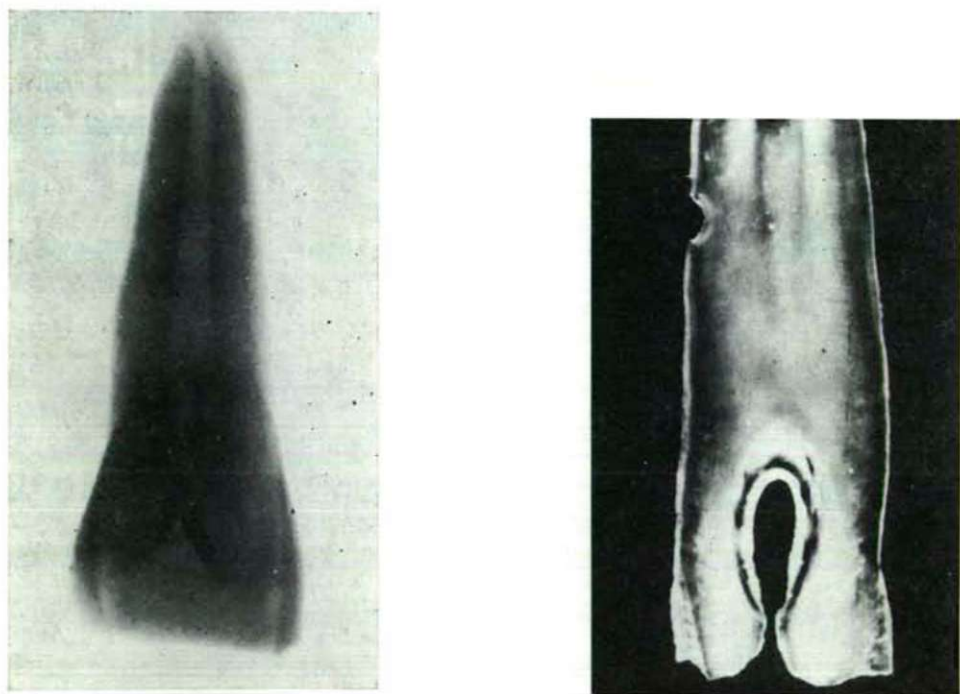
a) X-ray picture of the right upper double tooth from the Avar-age (inventory no. 1562, tomb no. 323, Fehértó-A.). Invagination of dilated form can be seen in it.
